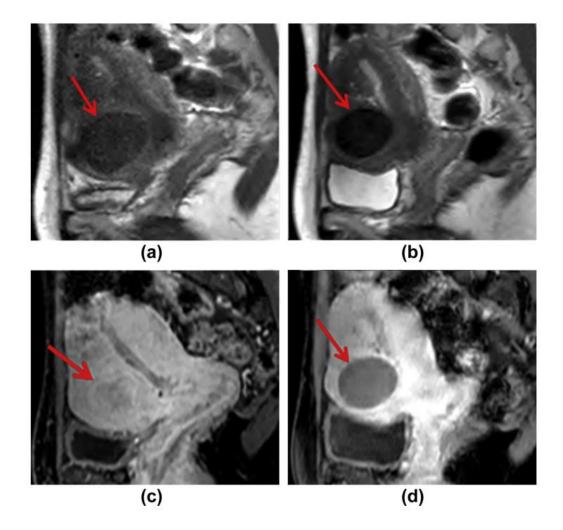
T2-weighted MRI images obtained from the same patient shown in Fig 2 in another sagittal plane. (a) The intramural fibroid of low T2 SI on pre-embolization images had undergone only 32% VR 9 months after UAE (b, d). (c) The signal of this fibroid appears hypointense on preembolization contrast-enhanced T1-weighted sequence (Kalina et al, 2018).
